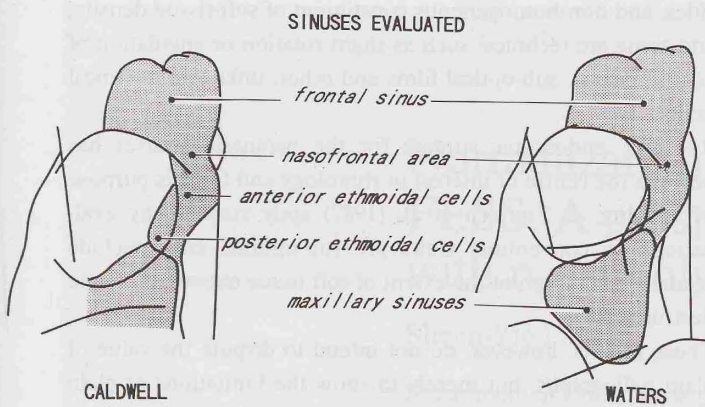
Radiographical anatomy of the paranasal sinuses.
